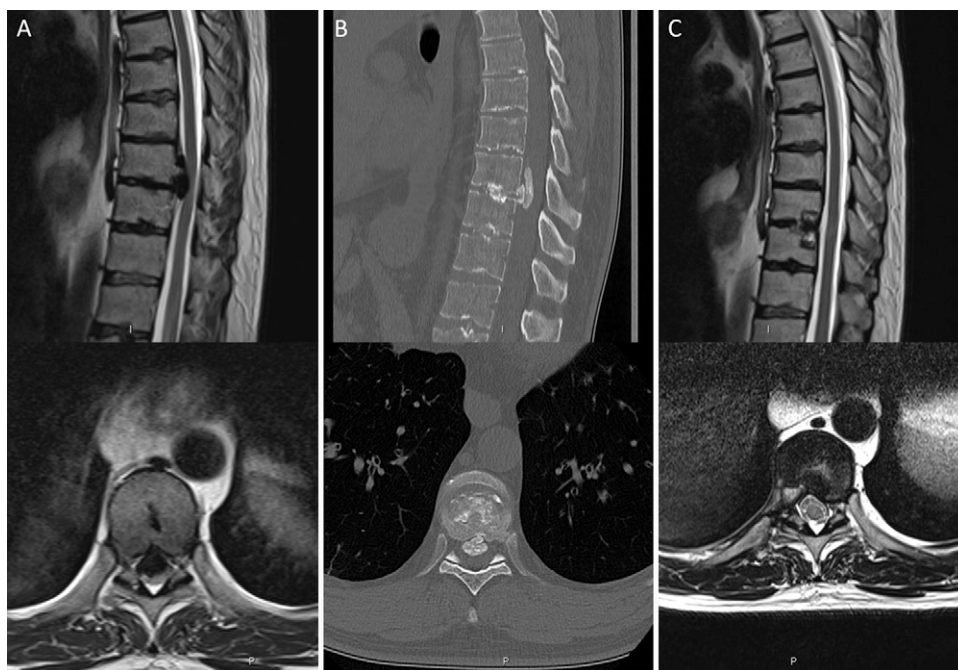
Case 1. A: Preoperative T2-weighted MRI demonstrates the thoracic spinal cord being impinged at T9–10 with flattening of the cord in the sagittal (*upper*) and axial (*lower*) views. B: Preoperative sagittal (*upper*) and axial (*lower*) CT shows calcification of the posterior longitudinal ligament and disc prolapse extending into the spinal canal. C: Postoperative sagittal (*upper*) and axial (*lower*) T2-weighted MRI shows the limited removal of the rib head and neck, the limited corpectomy cave and decompression of the thecal sac and cord.
